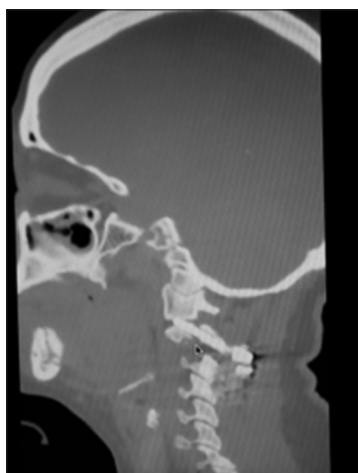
Sagittal CT scan that shows reduction of fractured elements
